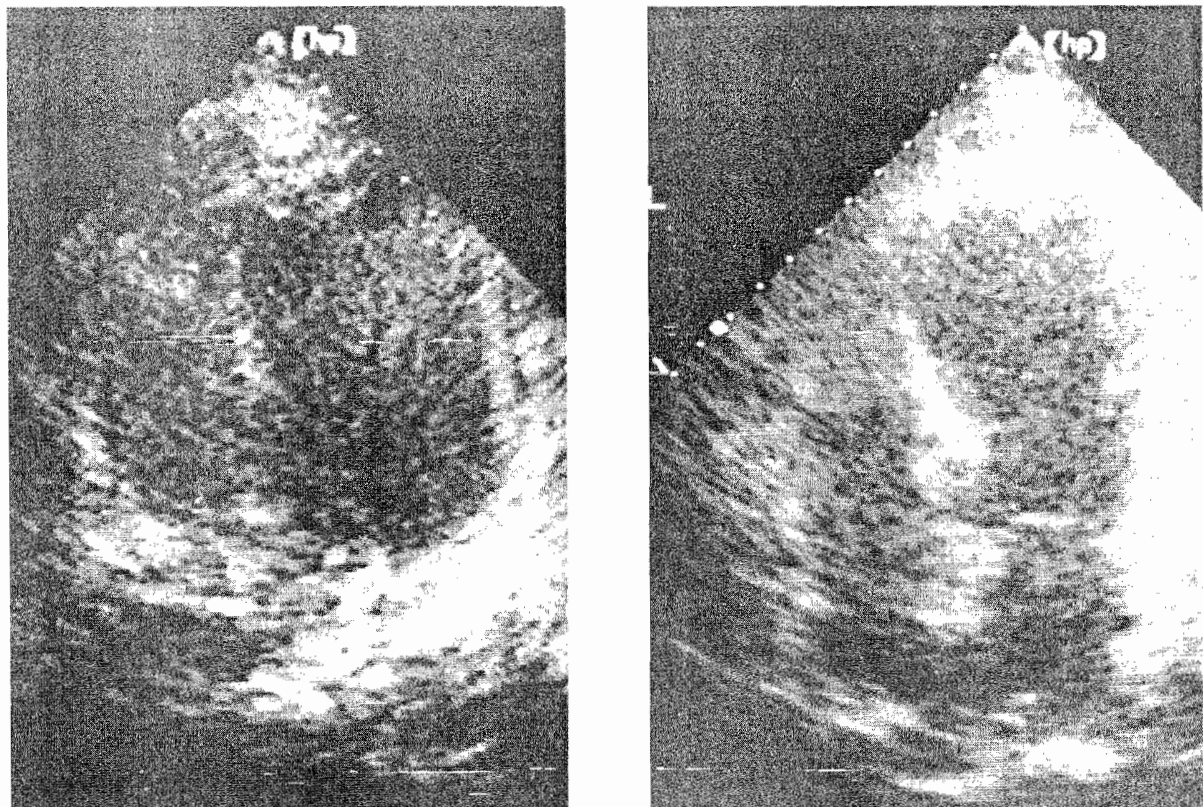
Echocardiograms performed on admission show an obvious thrombus in the left ventricular apex (left), and after the patient developed cerebral infarction, show a freely moving fragment of the thrombus (right) as a result of fibrinolysis.
